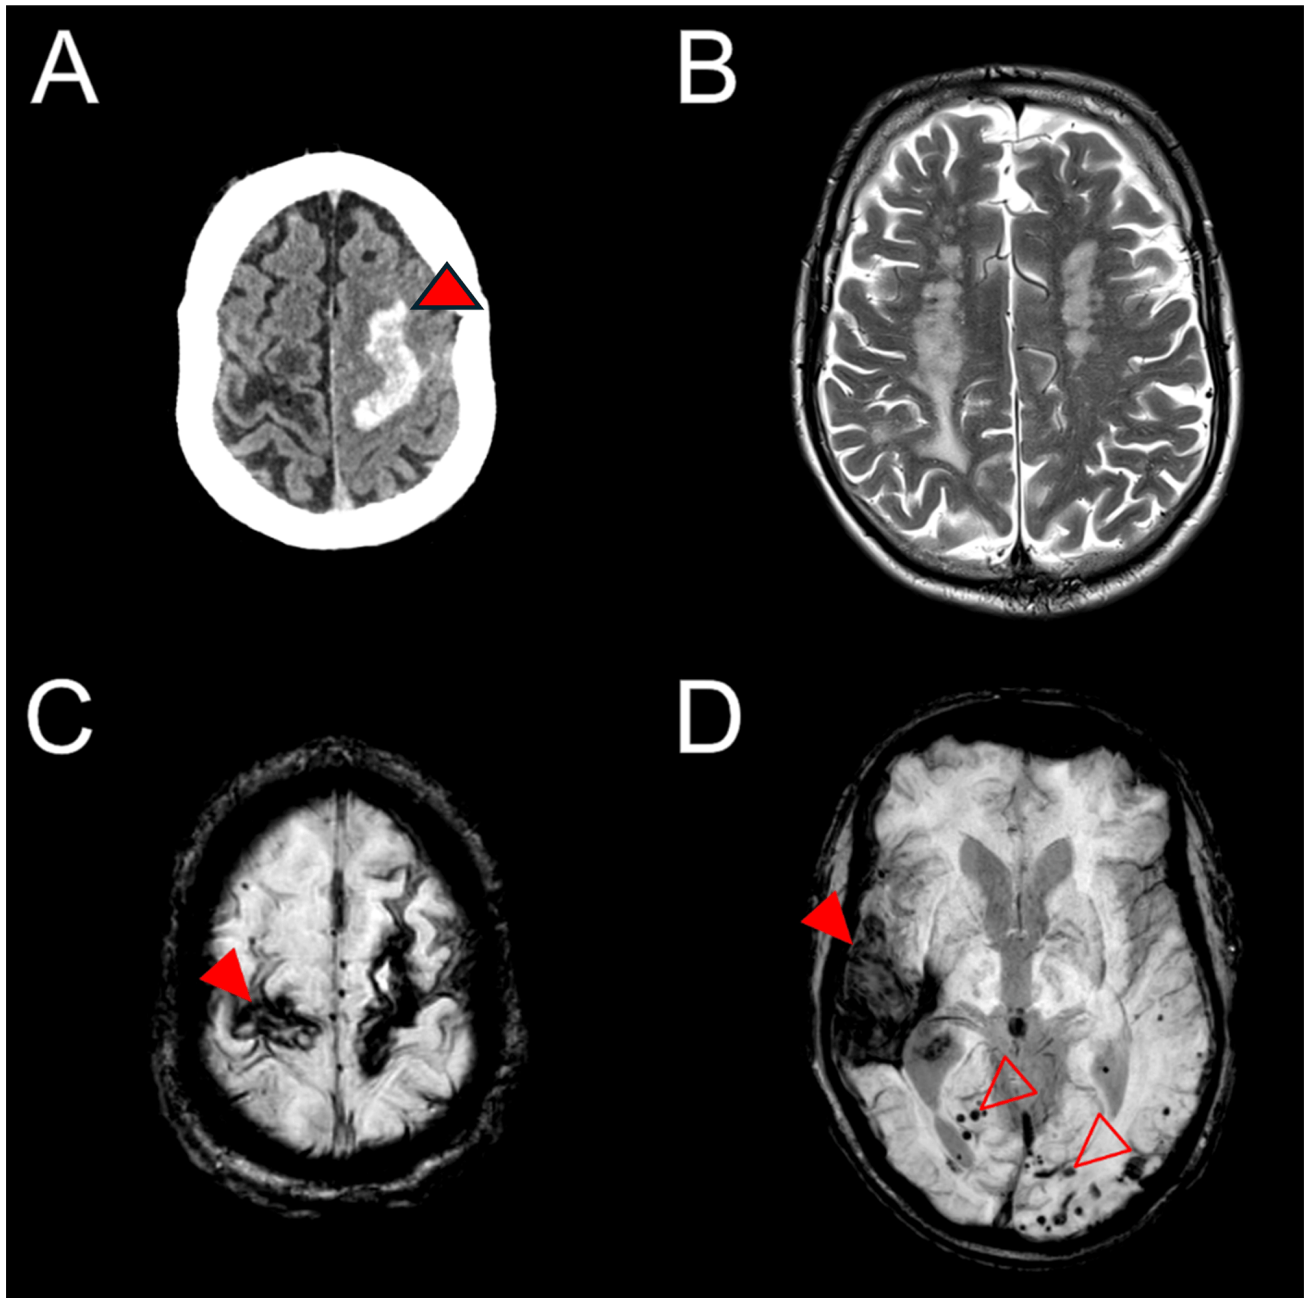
Acute CT and MRI imaging of patient in Case 2. CT showed an acute lobar haematoma in the left superior frontal gyrus (A, red arrow). T2-weighted imaging showed confluent white matter hyperintensity that was consistent with a severe burden of small vessel disease (B). Susceptibility weighted imaging showed, in addition to the recent haematoma in the left frontal lobe, an old intragyrus haematoma in the right frontal lobe (C, red arrow) and right temporal lobe (D, red arrow) as well as many lobar microhaemorrhages (D, open arrows).
